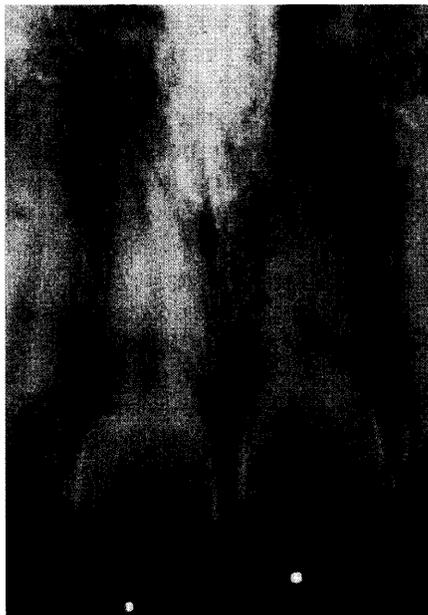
A periapical radiograph taken 5 years and 6 months post-replantation.
